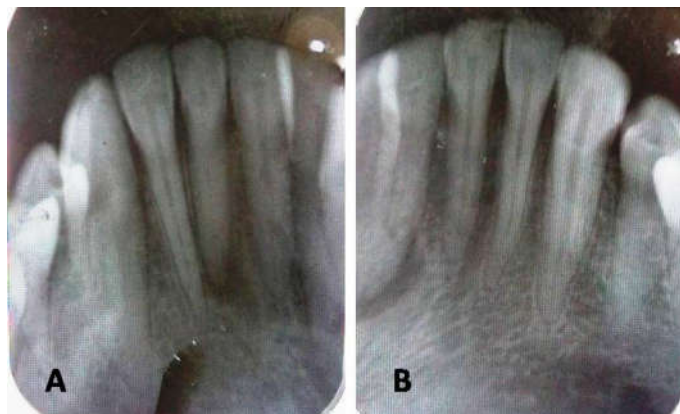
(A) and (B) shows no evidence of any pathology radiographically
